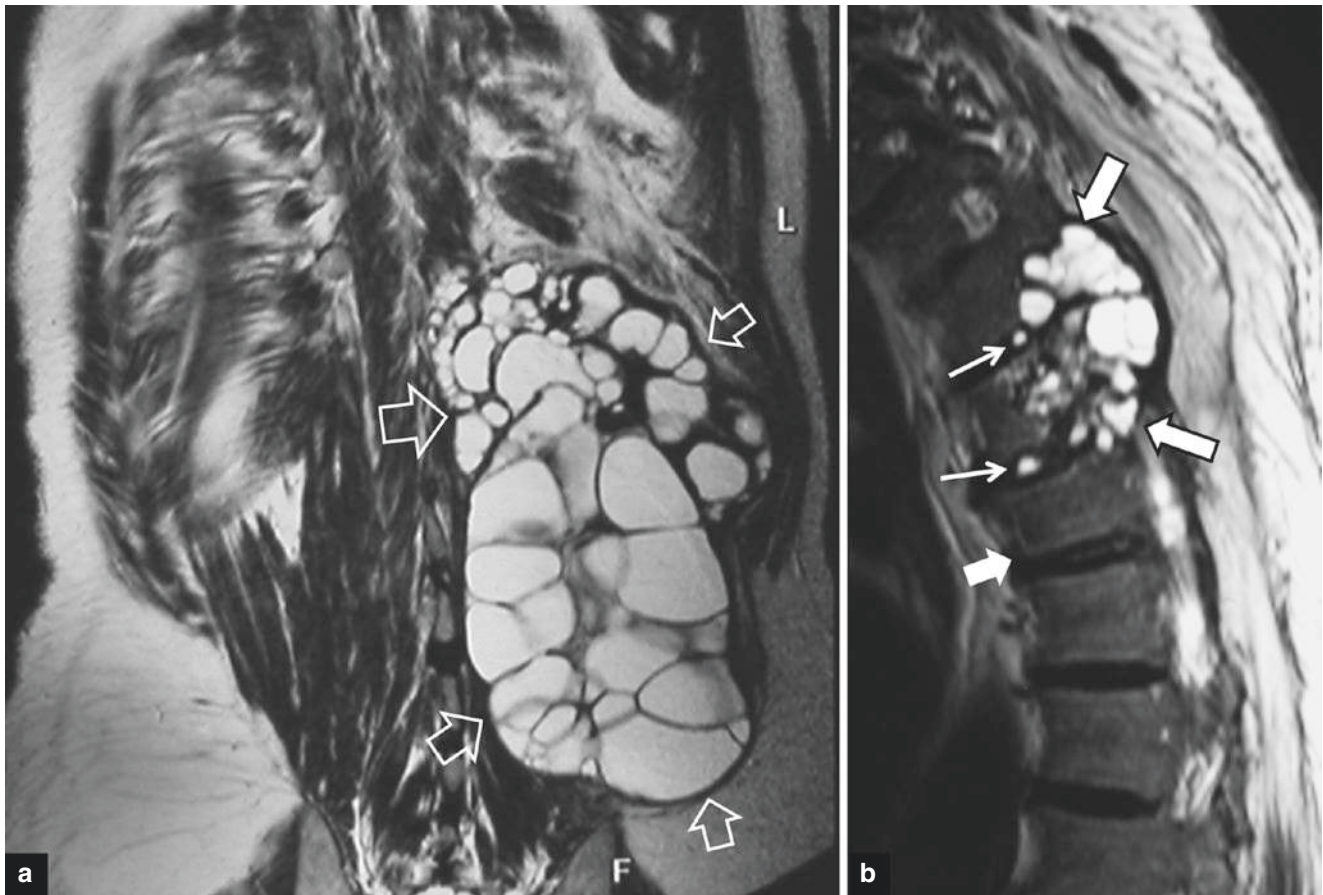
76-year-old man with previous soft tissue hydatid disease presenting 6 years postoperatively with dorsal back pain and gradually increasing weakness of left leg. (a) Coronal T2-weighted MR image
